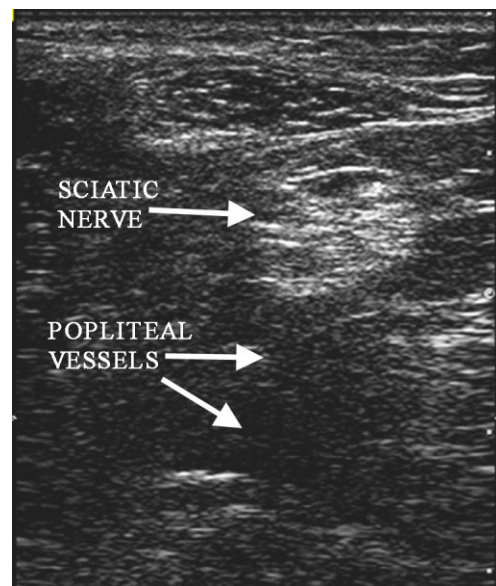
Sonogram of the sciatic nerve in the popliteal fossa. Note the well defined and rounded shape typical at this level.
